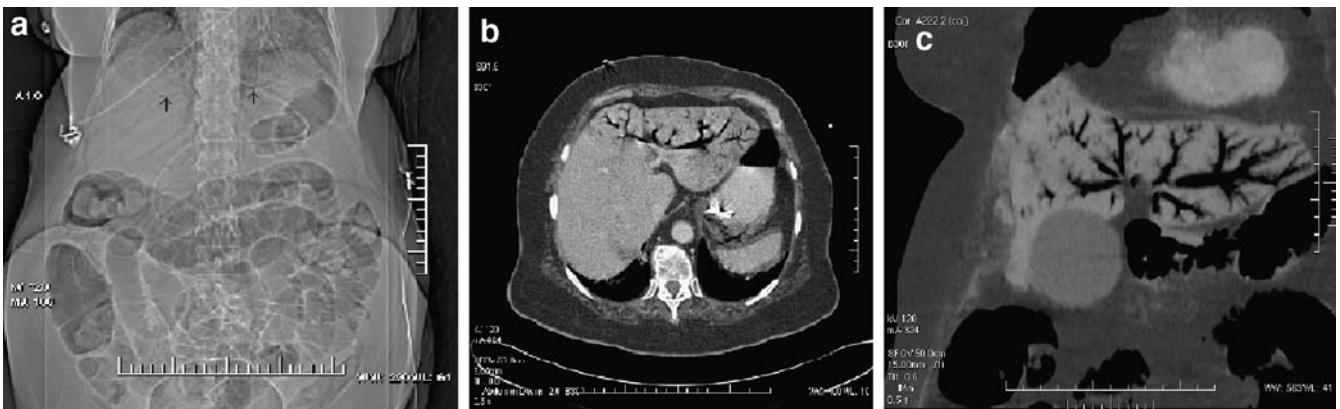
A 72-year-old woman (case #1) with atrial fibrillation and sepsis. a CT scanogram demonstrates multiple branching tubular lucencies in the liver (arrows). b CT scan during the portal venous phase shows a large volume of hepatic portal venous gas distributed
